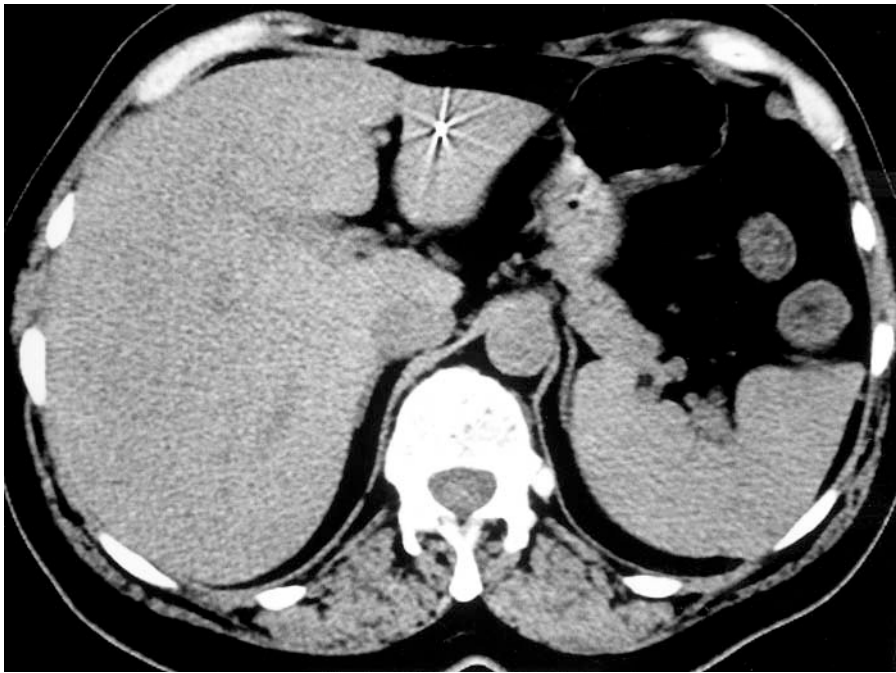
Abdominal computed tomogram confirming the presence of a metallic foreign body in the left lobe of liver.
